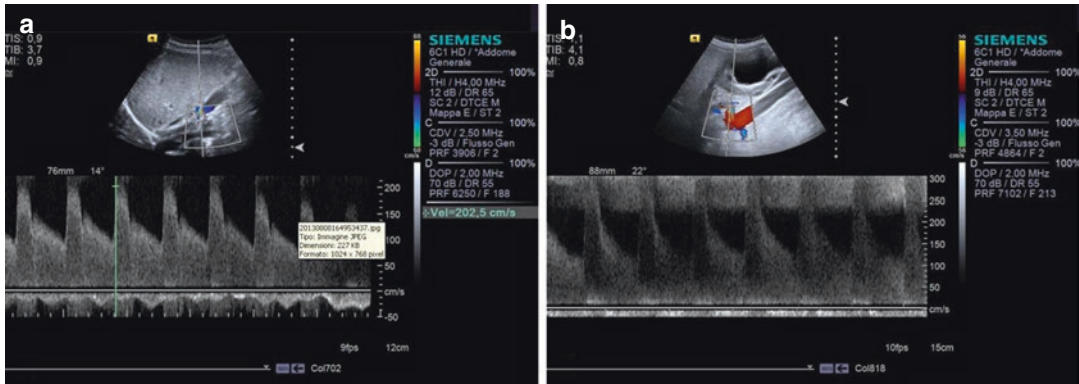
Renal artery stenosis (RAS): color Doppler features. (a) Spectral analysis highlights the marked PSV (>180 cm/s) and TDV (>120 cm/s) increases with spectral
